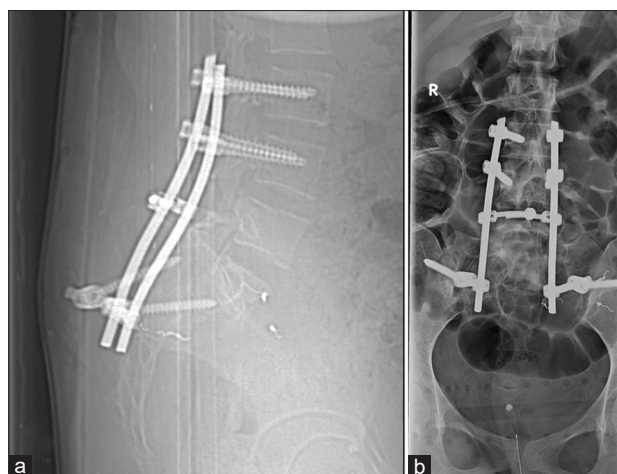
One-year postoperative standing radiographs showing the maintenance of correct alignment in both the lateral (a) and anteroposterior (b) projections
